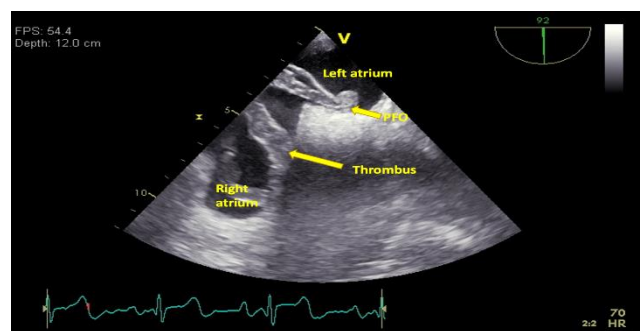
Transesophageal echocardiography in a 92° view. A large and mobile thrombus is seen across the foramen ovale.
